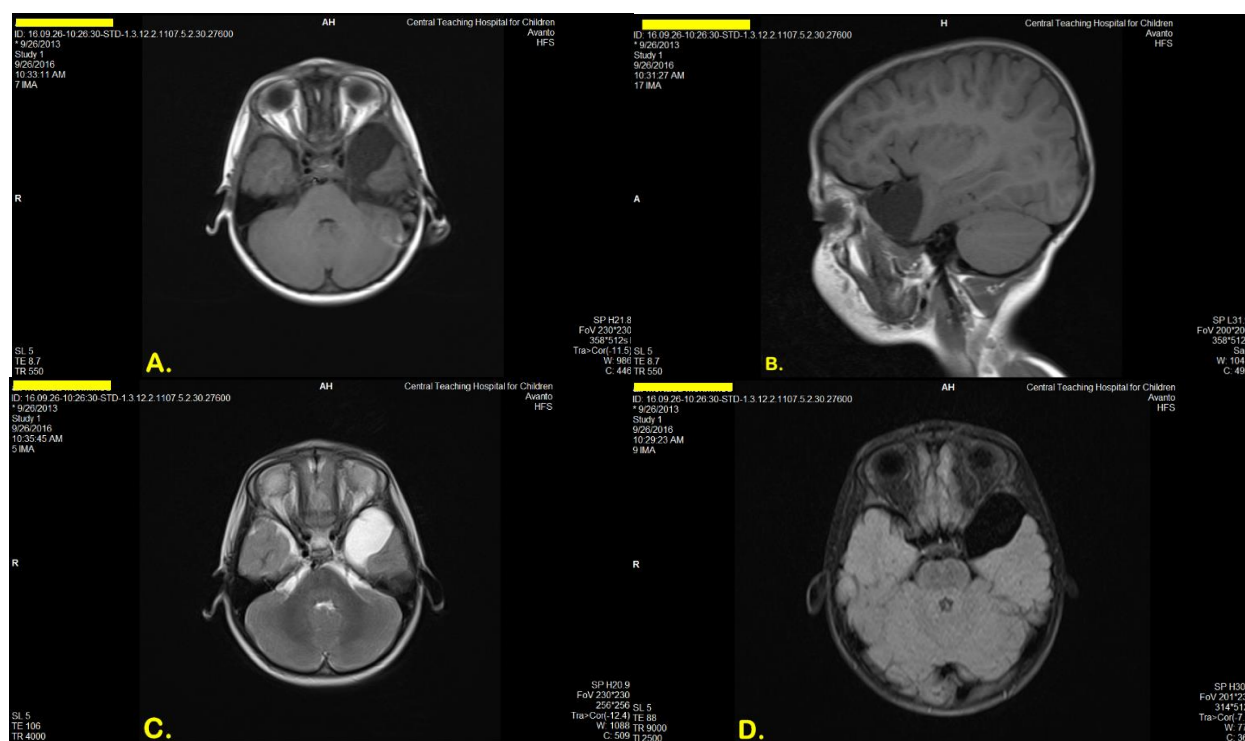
Left sided temporal arachnoids cyst in a 3-year child presenting with headache (A: axial T1, B: sagittal T1, C: axial T2, D: Axial FLAIR).
